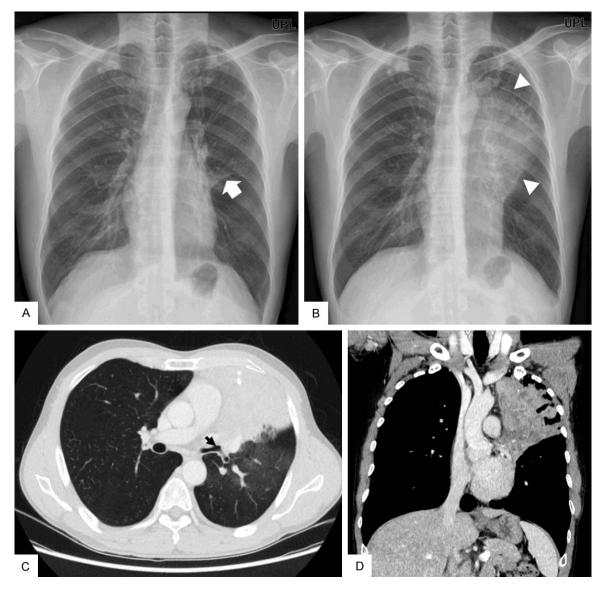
(A) Chest radiography obtained on the initial hospital visit revealed linear atelectasis around the left middle lung zones (white thick arrow). (B) Chest radiography and (C and D) computed tomography 15 months after the initial hospital visit demonstrated total collapse of the left upper lobe (white triangle in B) and obstruction of the left upper lobar bronchus (black thin arrow in C).
